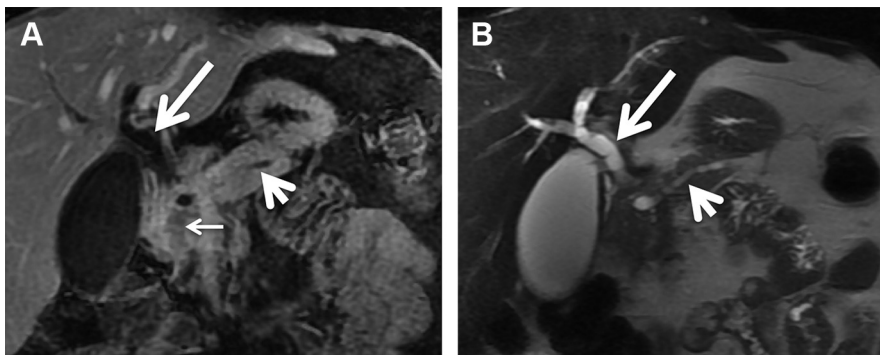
Classic imaging appearance of PDAC in a 45-year-old man. (A) Coronal gadolinium-enhanced T1-weighted image shows a hypoenhancing mass (*thin arrow*) in the head of the pancreas with pancreatic duct dilatation (*short thick arrow*) and bile duct dilatation (*long thick arrow*). (B) Coronal T2-weighted single-shot fast spin-echo image shows the pancreatic duct dilatation (*short thick arrow*) and bile duct dilatation (*long thick arrow*), caused by the obstructing mass, to better advantage.
